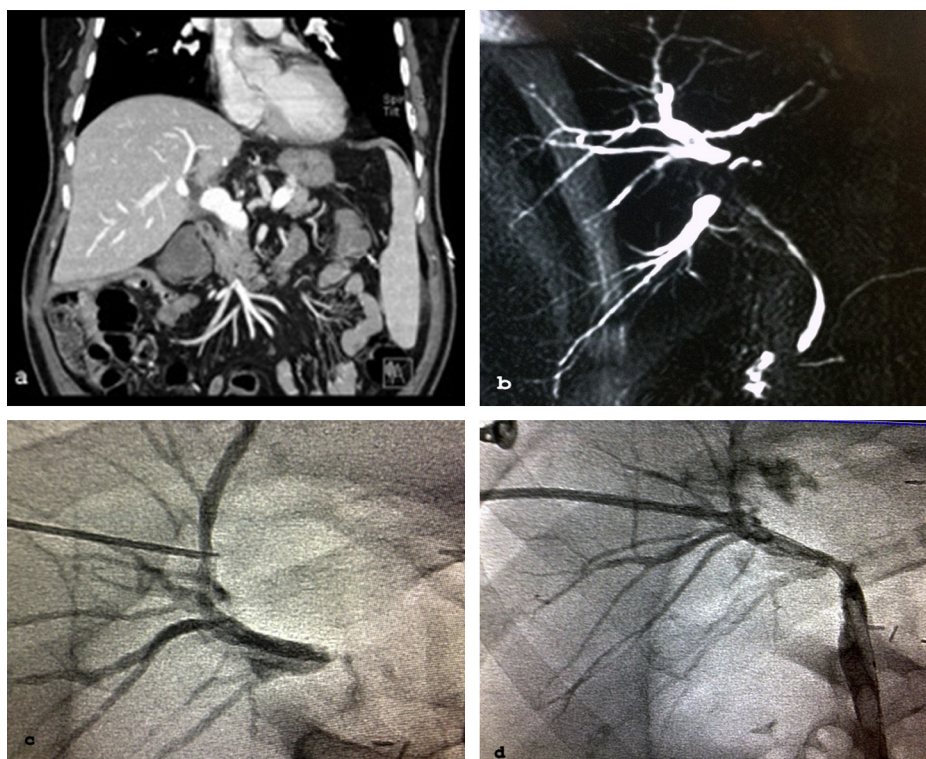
Sixty-one year old male patient complaining of jaundice and elevated liver enzymes. US showed intra-hepatic biliary radicles dilatation. (a) Coronal CT image showing dilated anterior bile duct. (b) MRCP image showing anastomotic stricture at the confluence of the anterior and posterior hepatic ducts. (c & d) PTD was done after failure of ERCP to bypass the stricture, with balloon dilatation and stent placement.
